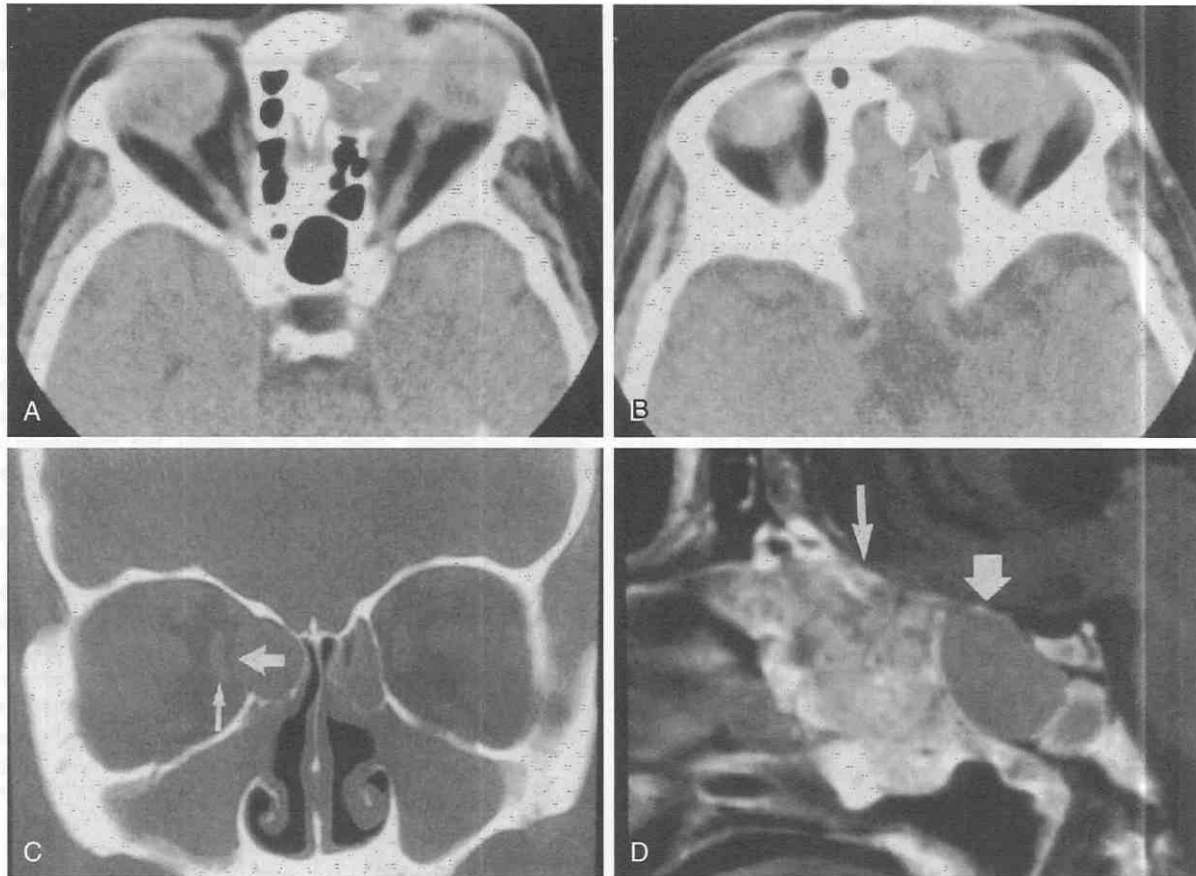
Mucocoele. Sixty percent of mucocoeles occur in the frontal sinus. *A*, An expansile mass is shown arising from the left frontal sinus with destruction of the lateral wall of the left frontal sinus (*arrow*). *B*, A slightly more superior image in the same patient depicts dehiscence of the posterior wall of the left frontal sinus (*arrow*), which is also the anterior wall of the anterior cranial fossa. *C*, An anterior ethmoid mucocoele is shown with lateral expansion into the right orbit and dehiscence of the right medial orbital wall (*large arrow*). There is medial displacement of orbital contents such as the medial rectus (*small arrow*), leading to diplopia. Mucocoeles may be the result of sinus obstruction from either inflammation or tumor. *D*, Postcontrast sagittal T1-weighted image (TR500, TE32) in the midline. There is solid enhancement in the region of the ethmoid air cells (*long arrow*), peripheral enhancement with central secretions within the sphenoid sinus (*short arrow*), and a mucocoele with linear peripheral enhancement secondary to sinus obstruction from tumor.
